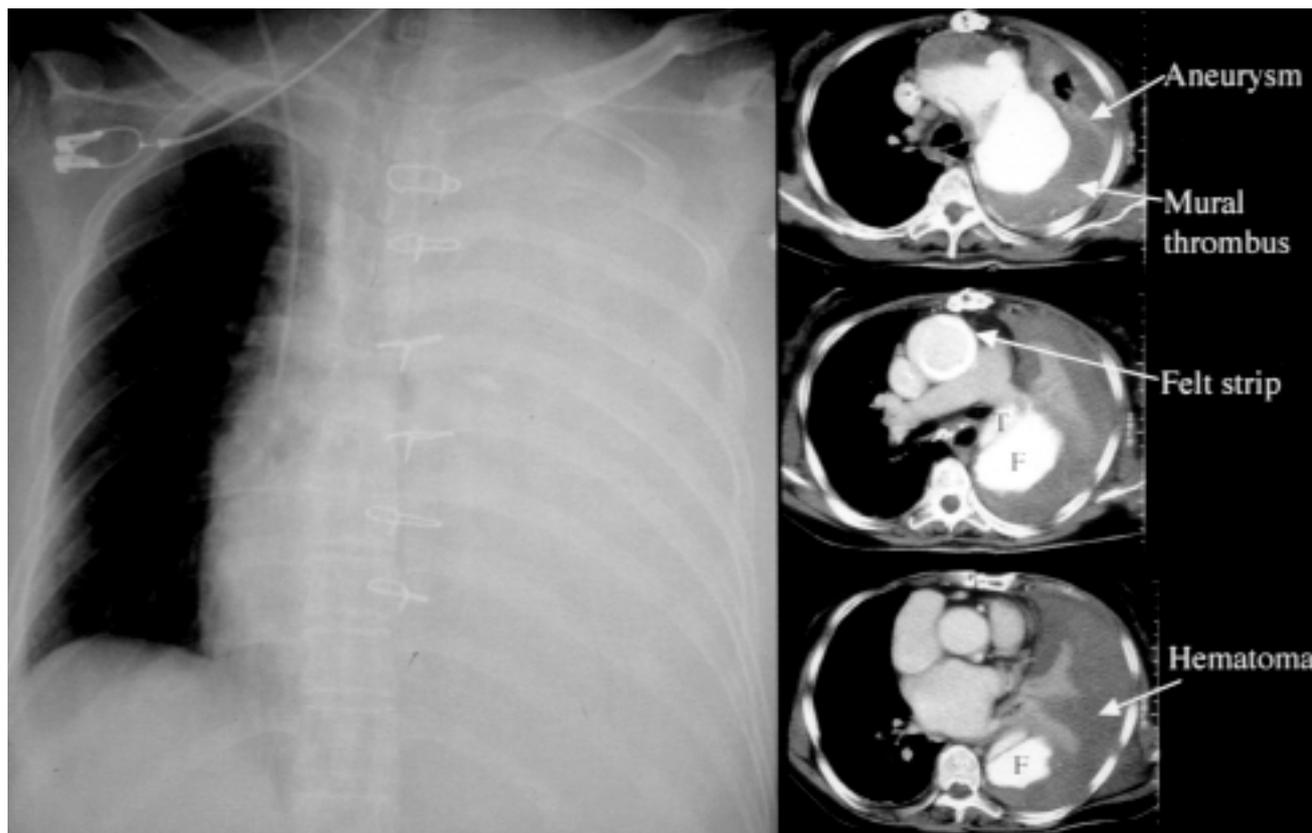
a: Chest X-ray showing massive left hemothorax.
